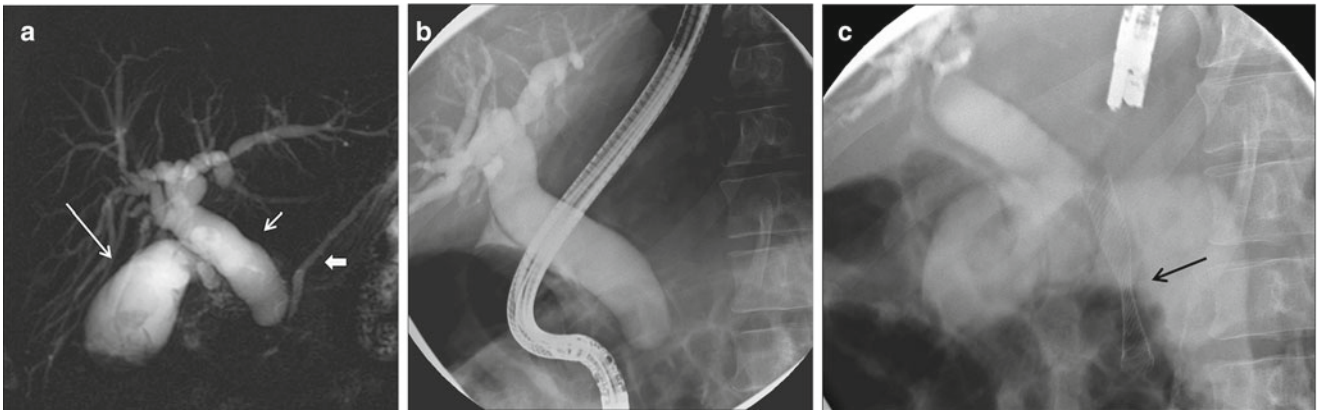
Seventy-one-year-old male presenting with jaundice. (a) Magnetic resonance imaging cholangiopancreatography showing dilated intrahepatic ducts and common duct (*short thin arrow*). There is abrupt tapering in the distal portion from benign stricture due to inflammation associated to peptic ulcer disease. The pancreatic duct
